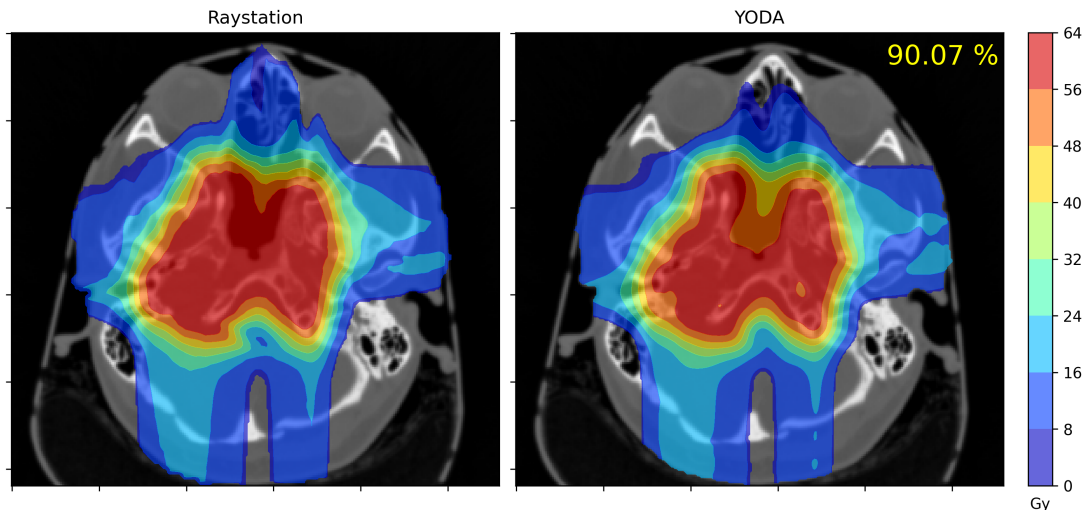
Dosimetric comparison between RayStation and YODA for the Patient 4. The figure displays RayStation (on the left) and YODA (on the right) two-dimensional dose cuts, overlaid on the corresponding CT slice. The figure displays in the top right corner of the YODA plot, the three-dimensional gamma index passing rate using 2 mm, 2 % and 10 % cut-off.
